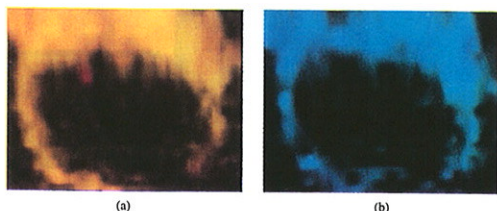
3-D tissue Doppler imaging. Cross-sectional slices through the left ventricle in (a) start-systole and (b) mid-diastole. The tissue velocity vectors are perpendicular to the slices.
